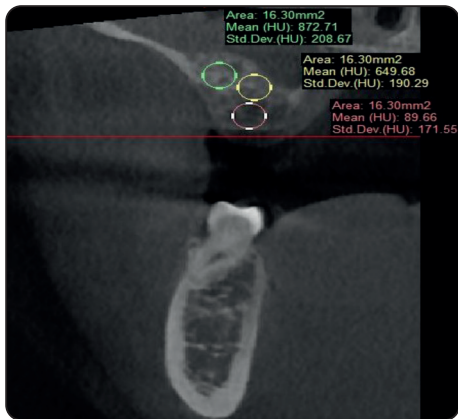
Coronal cut of CBCT showing the density measurements at the grafted maxillary sinus floor immediate postoperative
